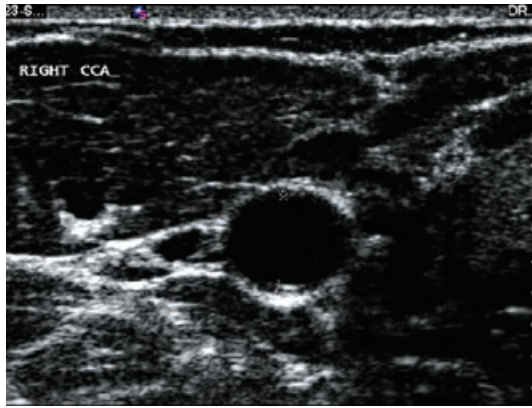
Transverse scan of the right CCA by B-mode ultrasonography; right CCA demonstrating increased wall thickness.
